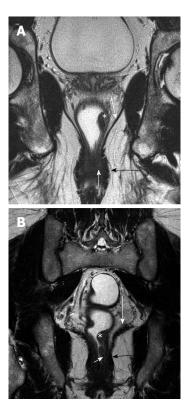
Coronal section T2 weighted magnetic resonance imaging to see level of tumor for planning surgery. A and B show tumor (asterisk) along the left lateral wall, that reaches up to the internal sphincter (short white arrows) in B, but spares it in A. The uninvolved external sphincter (darkly hypointense) is shown by black arrows. The long white arrows in A and B shows the spared levator ani.
